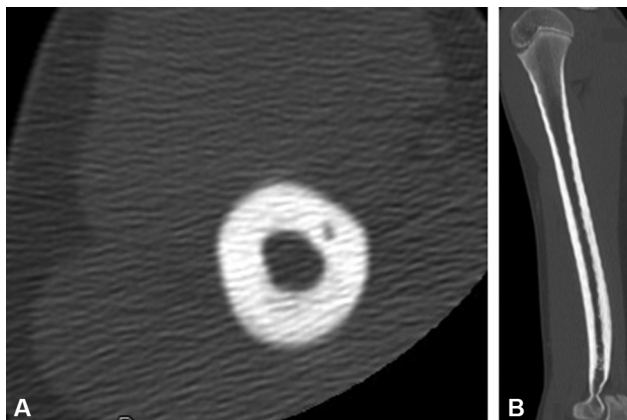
Axial (A) and sagittal CT (B) images showing fracture consolidation and persistent thickening of the posterior cortex.
